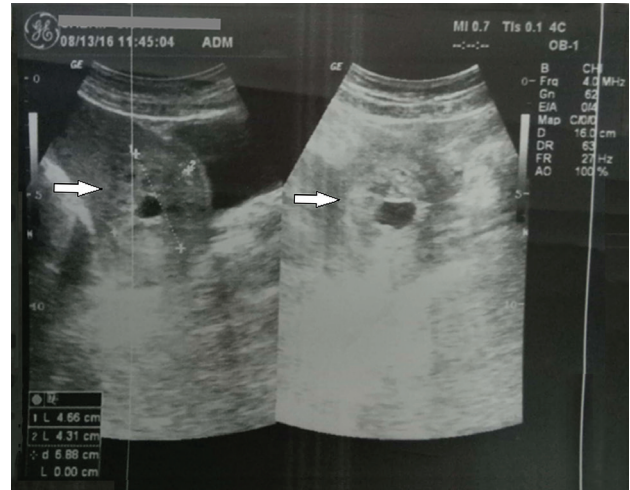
Repeat ultrasound three days later. Cervix distended and showing a cystic structure with thick echogenic rim, indicating gestational sac which appears to be adherent to the anterior wall of cervix.
